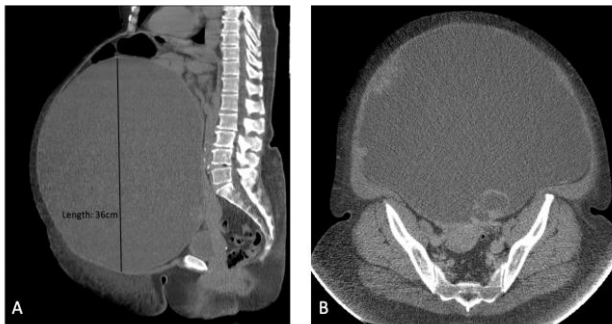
A and B. Sagittal and axial contrast-enhanced CT images showing the presence of the giant ovarian well-capsulated and inhomogeneously hypodense lesion (A) with evidence of few hypervascular parietal solid nodules (B).
